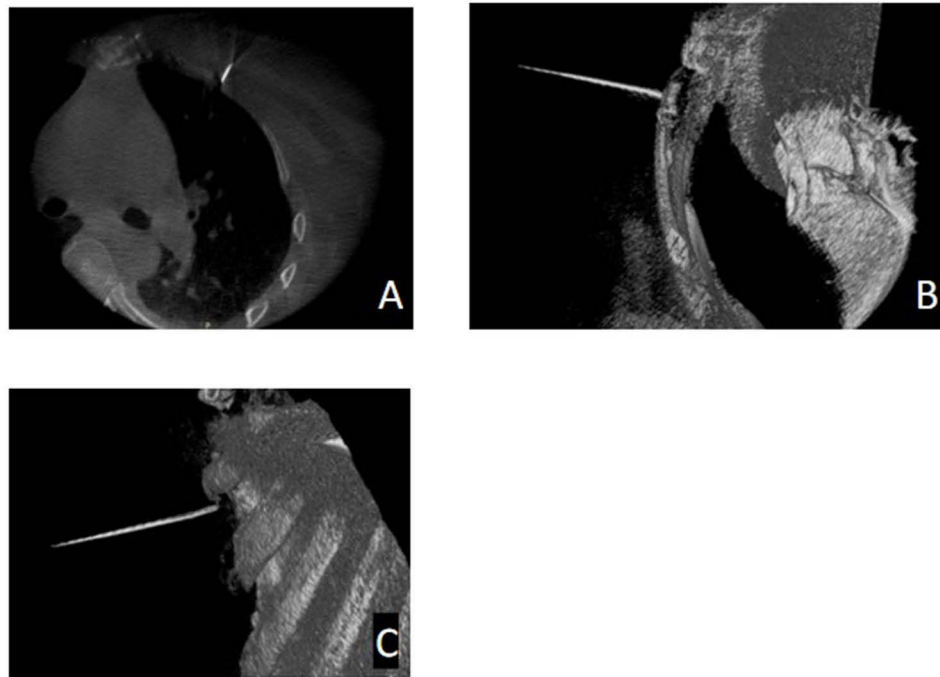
Corrected cannula position after O-arm CT-guided adjustment. (A) CT of the cannula position. (B) 3D CT of the cannula position. (C) 3D CT of the cannula position.
